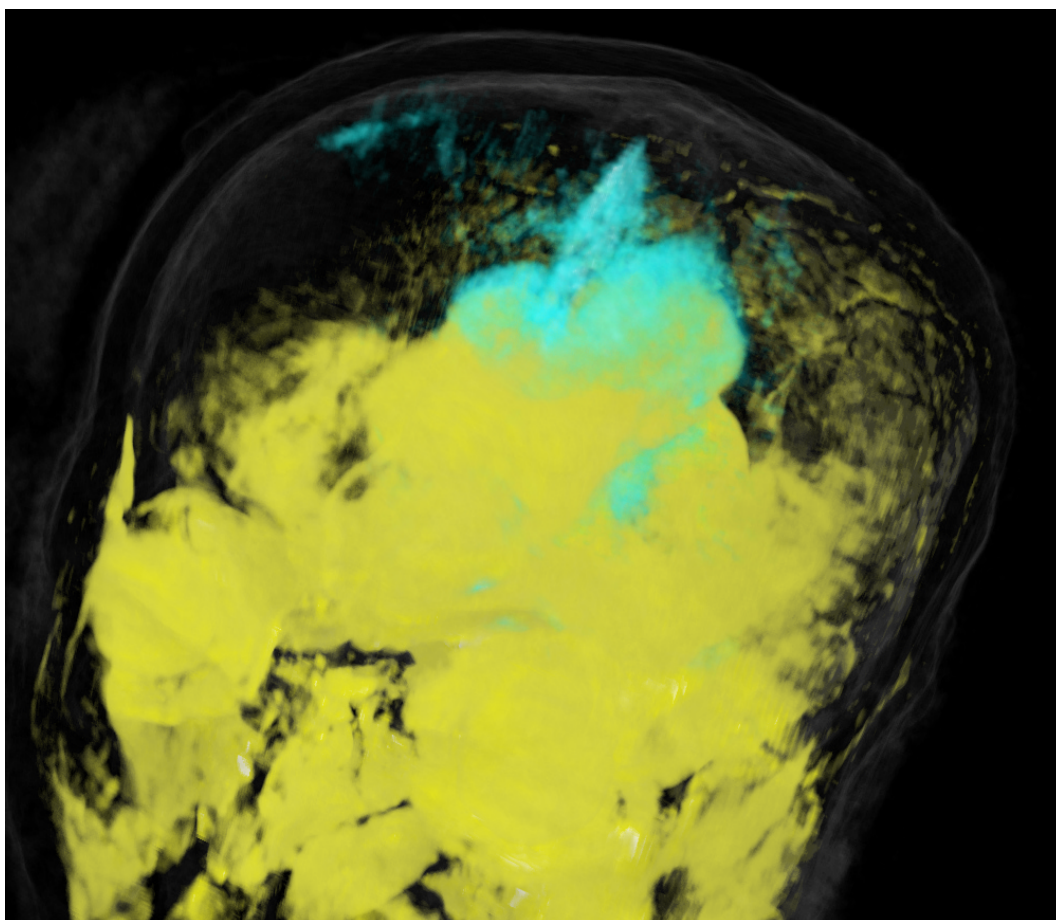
Dataset Tumor2. Volume renderings of MRI T2 (*yellow*) and UST #1 (*cyan*).
